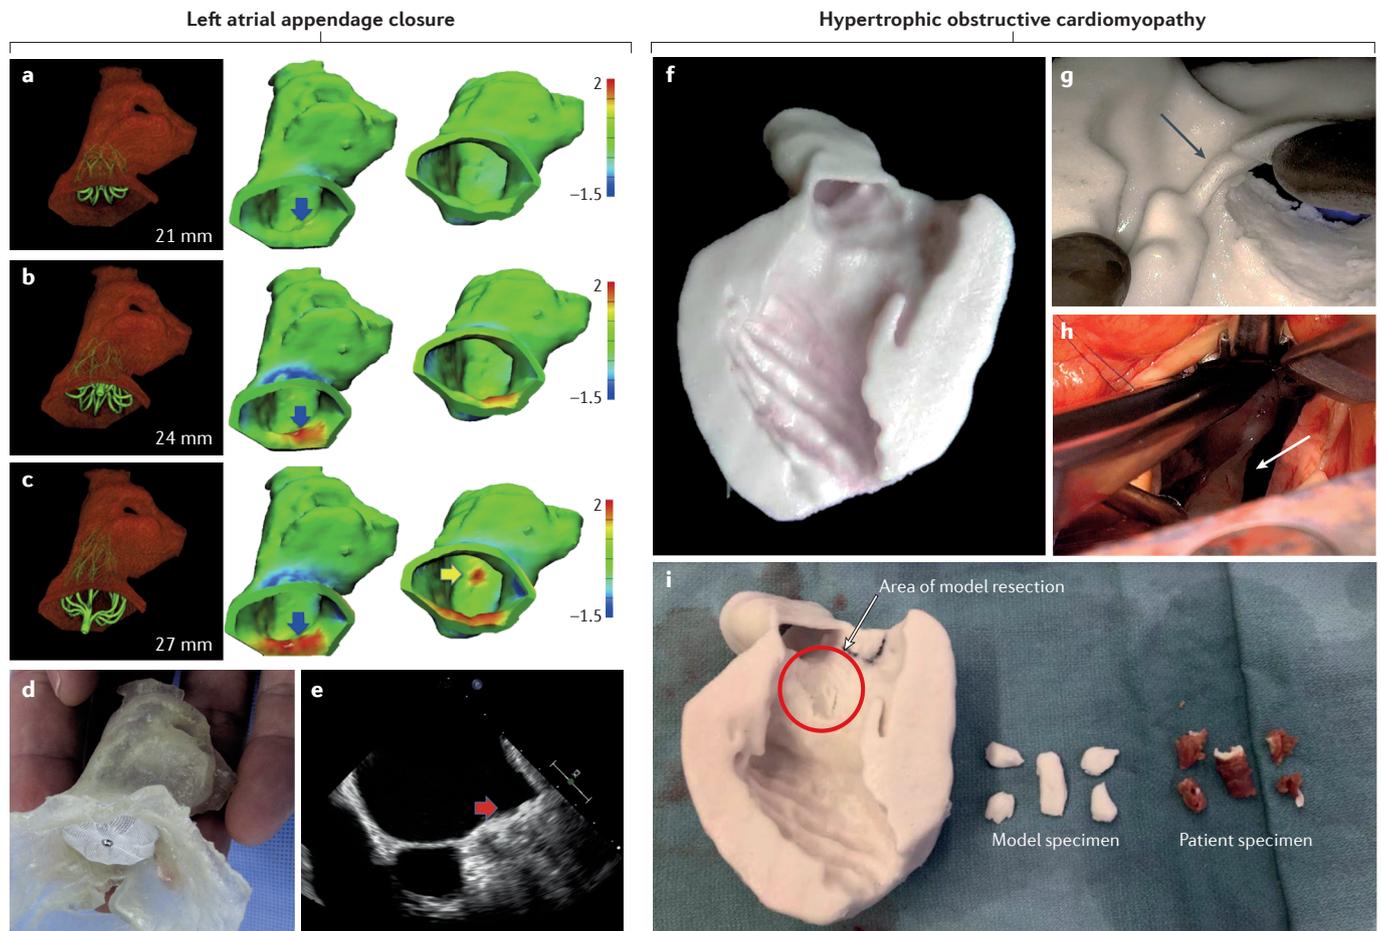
3D printing-assisted intervention and surgery planning of structural heart diseases. a–e | Sizing of a Watchman device (Boston Scientific, USA) for left atrial appendage closure with a patient-specific 3D-printed model. Devices in sizes 21 mm (panel a), 24 mm (panel b), and 27 mm (panel c) were deployed in a flexible atrial model derived from CT images. Anatomical distortion was calculated for each device, creating a 3D map colour-coded according to the degree of deformation produced. The 21-mm device applies minimal radial force at the appendage orifice (blue arrow), whereas the barbs of the 27-mm device apply localized stress to the appendage wall (yellow arrow). Panel d shows the Watchman device placed within the flexible 3D-printed model. Transoesophageal echocardiography after the procedure demonstrates complete closure with a 24-mm device (panel e, red arrow). f–i | 3D printing-assisted septal myectomy in a patient with obstructive hypertrophic cardiomyopathy. A 3D porous scaffold of the anatomy of interest was fabricated and infused with a mixture of silicone and a blend of two hydrogels approximating the consistency of the cardiac
